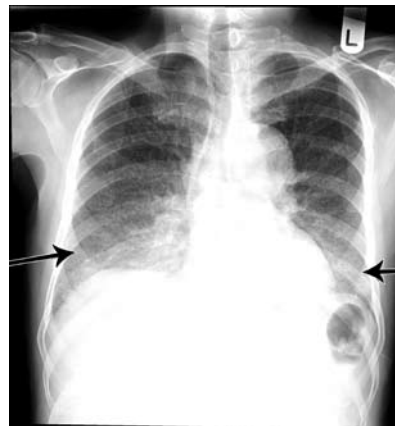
Chest x-ray showing diffuse bilateral nodular opacities mainly over the bases (arrows)
